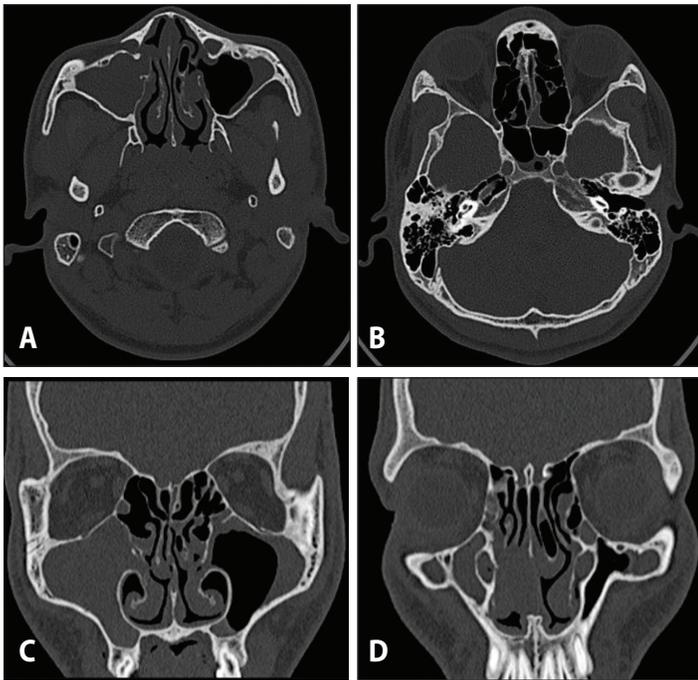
Pre-operative CT scans: A, B. axial views; C, D. coronal views.
